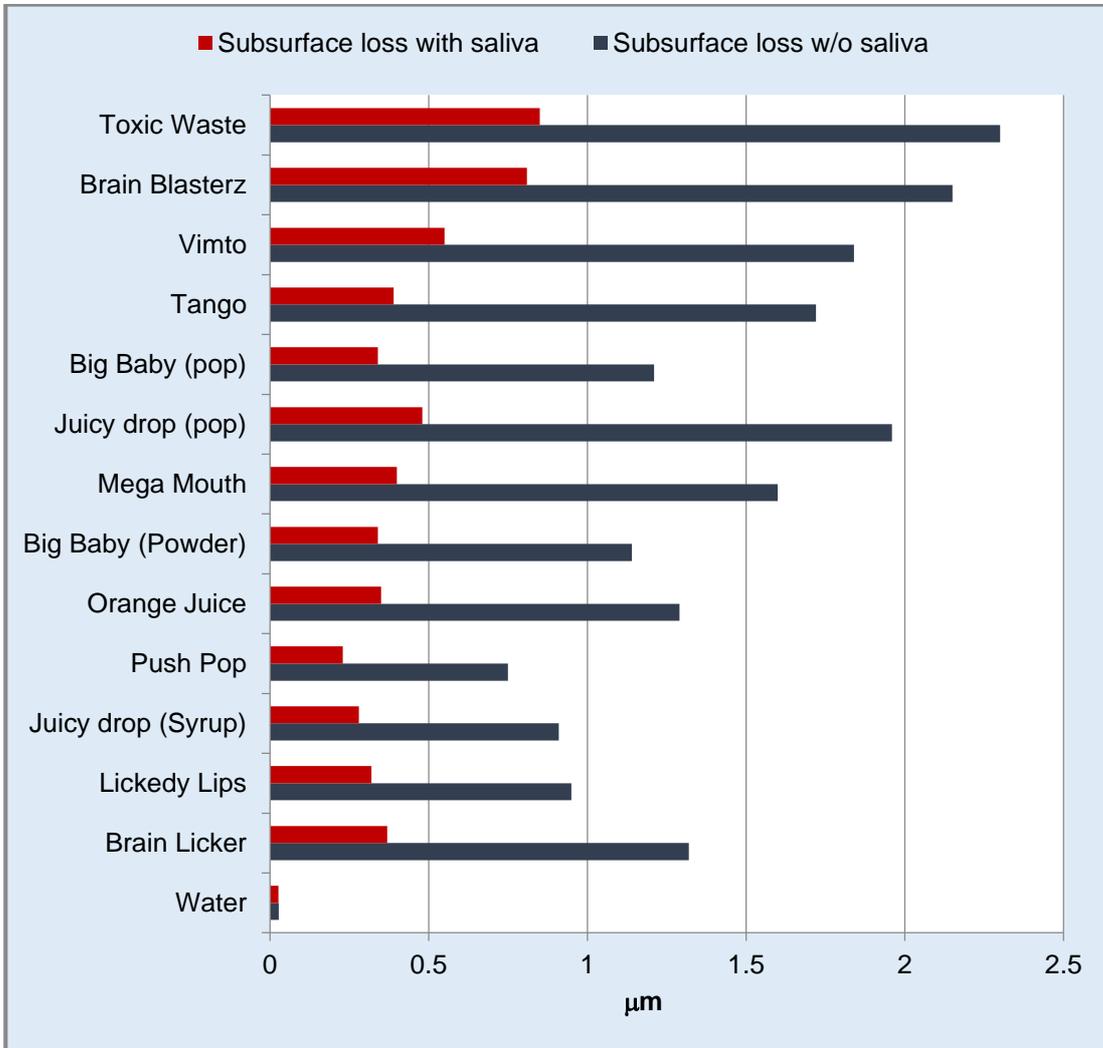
Total subsurface enamel loss with initial placement in saliva prior to the ultrasonication (Group A) and immediate ultrasonication without placement saliva (Group B).
